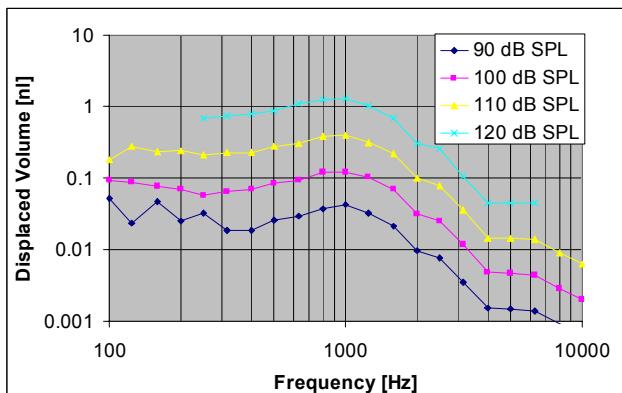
Middle ear transfer function assessed on a fresh human temporal bone [1]. Different sound pressure levels were applied in front of the tympanic membrane and the displacement of the stapes was measured with a laser Doppler vibrometer. The displacement was converted into displaced volume by multiplication with oval window area of 3.2 mm².
